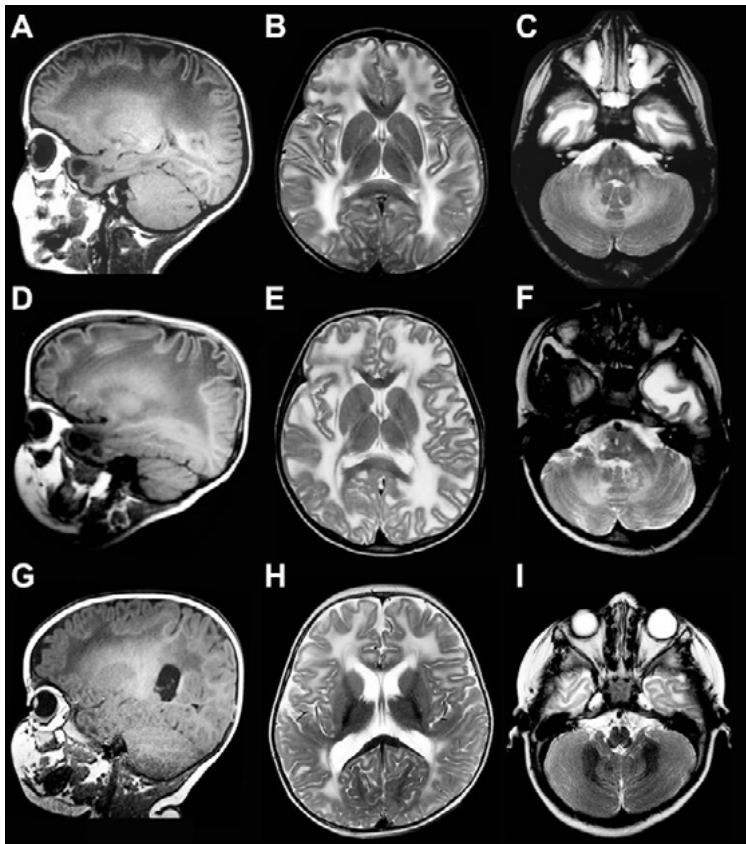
MRI characteristics. MRI findings in an MLC1 patient at the age of 3 years (top), an MLC2A patient at the age of 6 years (middle) and an MLC2B patient at the age of 10 months (bottom). Sagittal T₁-weighted images show anterior-temporal and frontoparietal cysts in the MLC1 patient (A), an anterior-temporal cyst in the MLC2A patient (D) and some near-cystic rarefaction in the anterior-temporal region in the MLC2B patient (G). The T₂-weighted axial images of the hemispheres show diffuse white matter abnormalities with some swelling (B, E, H). The sagittal images show some sparing of the subcortical white matter in all patients, especially in the occipital region (A,D,G); in the MLC2B patient the white matter is relative preserved in the occipital region (G). The classic MLC patients have a double-line-shaped abnormal signal of the posterior limb of the internal capsule (B, E), while the signal is normal in the MLC2B patient (H). The T₂-weighted axial images of the cerebellum show a mildly hyperintense signal of the cerebellar white matter in the classic MLC patients (C, F) and a normal signal in the MLC2B patient (I).
